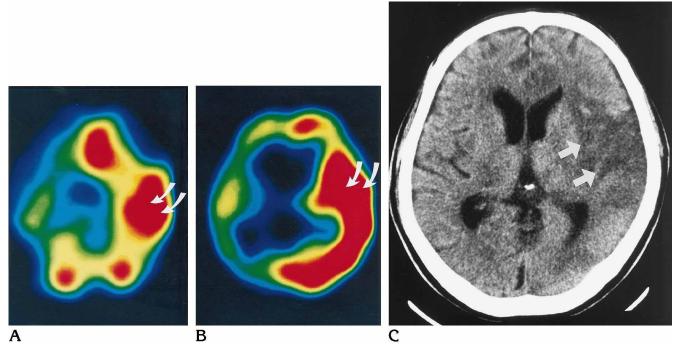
Case 2: 70-year-old man with atrial fibrillation and sudden onset of seizure and right-sided hemiplegia. *A* and *B*, HMPAO SPECT scans 2 days after the onset of stroke show marked elevation of ^{99m}Tc-HMPAO uptake (*arrows*) in the left frontal, temporal, parietal, and occipital lobes.
